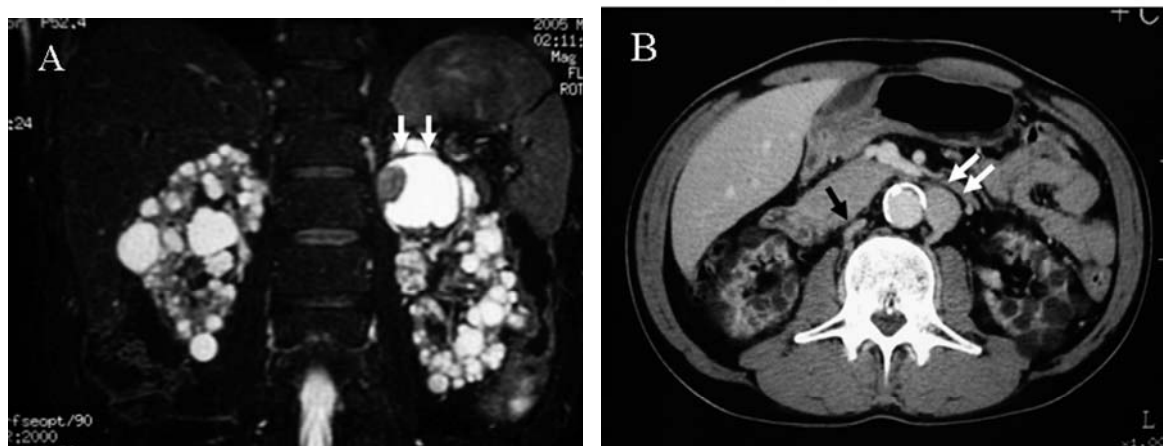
(A) Abdominal MRI showed multiple renal cysts due to ACDK and a cystic renal tumor (white arrows) in the upper pole of the left kidney. (B) Abdominal CT. There were duplicate IVC located on both sides of the aorta. The left IVC (white arrows) was bigger than the right one (black arrow).
